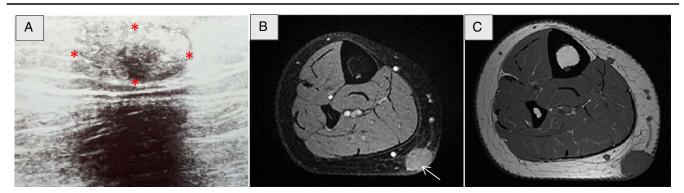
(A) Gray scale US image revealing a well-circumscribed heterogeneous, hypoechoic mass (calipers), with a posterior acoustic shadow. The MRI findings indicate that the lesion exhibited hyperintensity (arrow) in T1 injected sequences (B) and hypointensity in T1 sequences (C).
